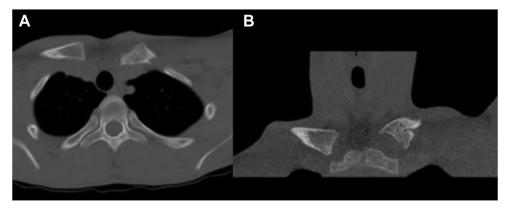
Axial (A) and coronal (B) CT scan 7.5 months after surgery demonstrating maintained concentric reduction of the left sternoclavicular joint. CT, computed tomography.
